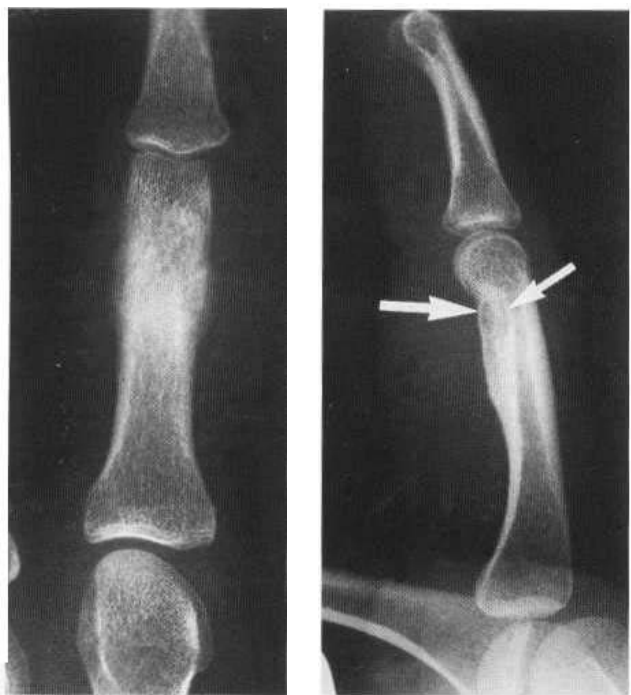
Osteoid osteoma in the proximal phalanx of the index finger. (A) The AP radiograph shows ill-defined periosteal new bone formation and some sclerosis involving the proximal phalanx. Marked soft-tissue oedema is also evident. (B) The lateral radiograph demonstrates apparent expansion and scalloping of the distal anterior cortex of the proximal phalanx with trabecular sclerosis distal to the radiolucent nidus (arrows).
